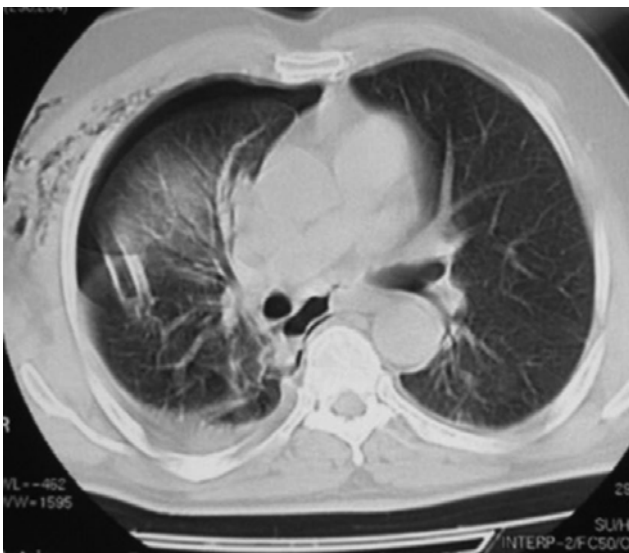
Chest CT scan demonstrated right sided hydropneumothorax, and a small amount of air in the mediastinum. Chest tube is located in right pleural space.
